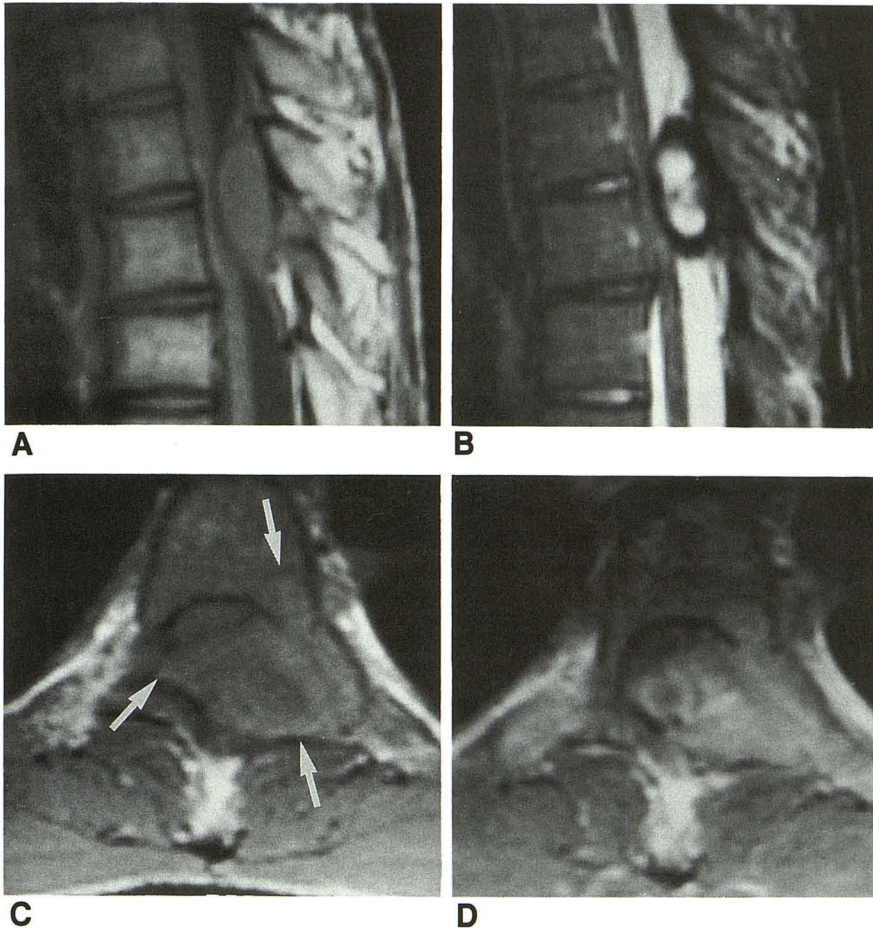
A, Short repetition time/echo time 550/19 sagittal MR image (1.5 T) shows an extradural tumor with low to medium signal intensity. The tumor extended into the spinal canal, compressing the posterior margin of the spinal cord.
